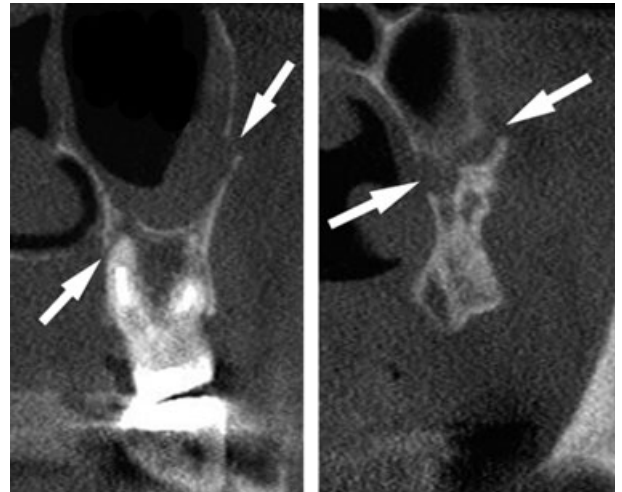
Computed tomography coronal sections of the maxillary tuberosity region showing evidence of fractures (arrows).
